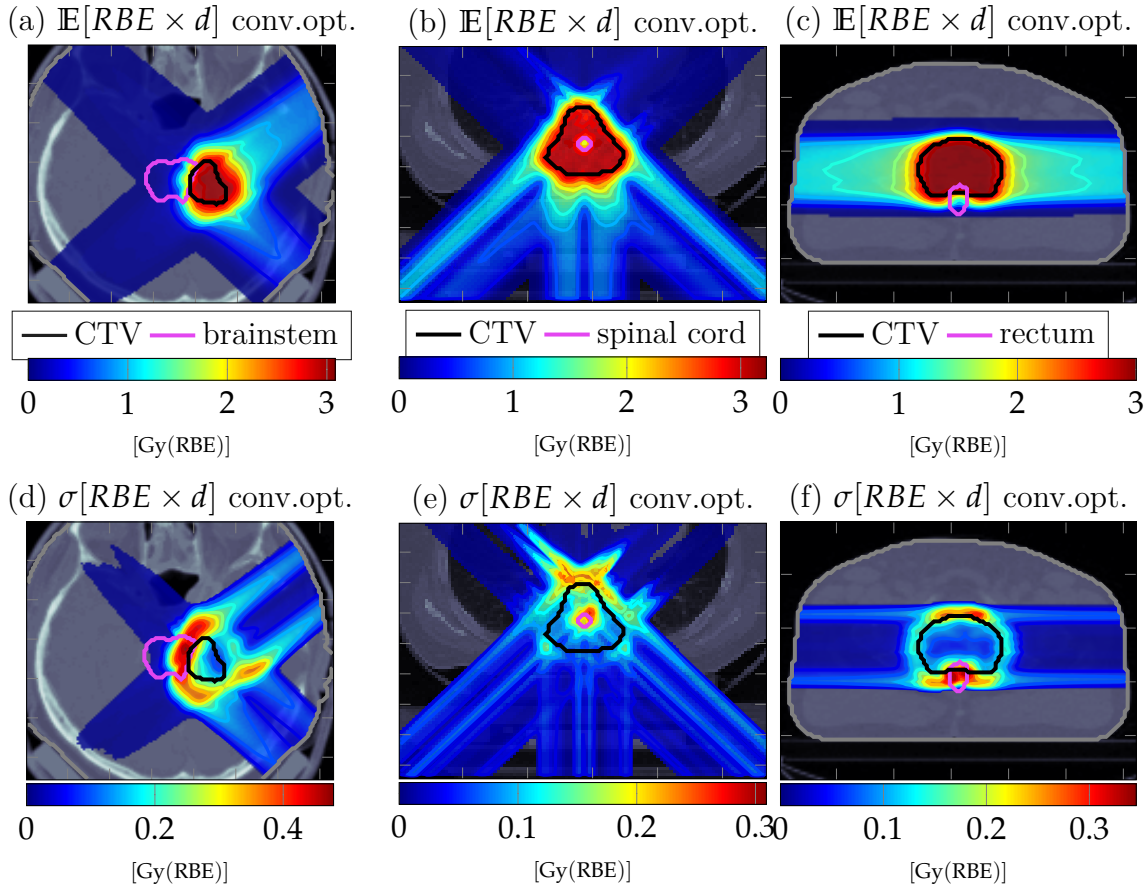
Transversal slices at iso-center of three scanned carbon ion therapy treatment plans as defined in Table III.2. For the standard deviation calculation a different number of fraction were assumed each time ($f=1,5$ and 20). The CT image is overlaid with transparent dose colorwash, solid isodose lines and contours. Plots in the upper row (a), (b) and (c) represent the expected RBE weighted dose ($\mathbb{E}[RBE \times d]$) assuming physical range and physical lateral errors. The corresponding standard deviation ($\sigma[RBE \times d]$) of these conventionally optimized treatment plans are shown in the lower row in (d), (e) and (f). (Wieser et al., 2017b)
